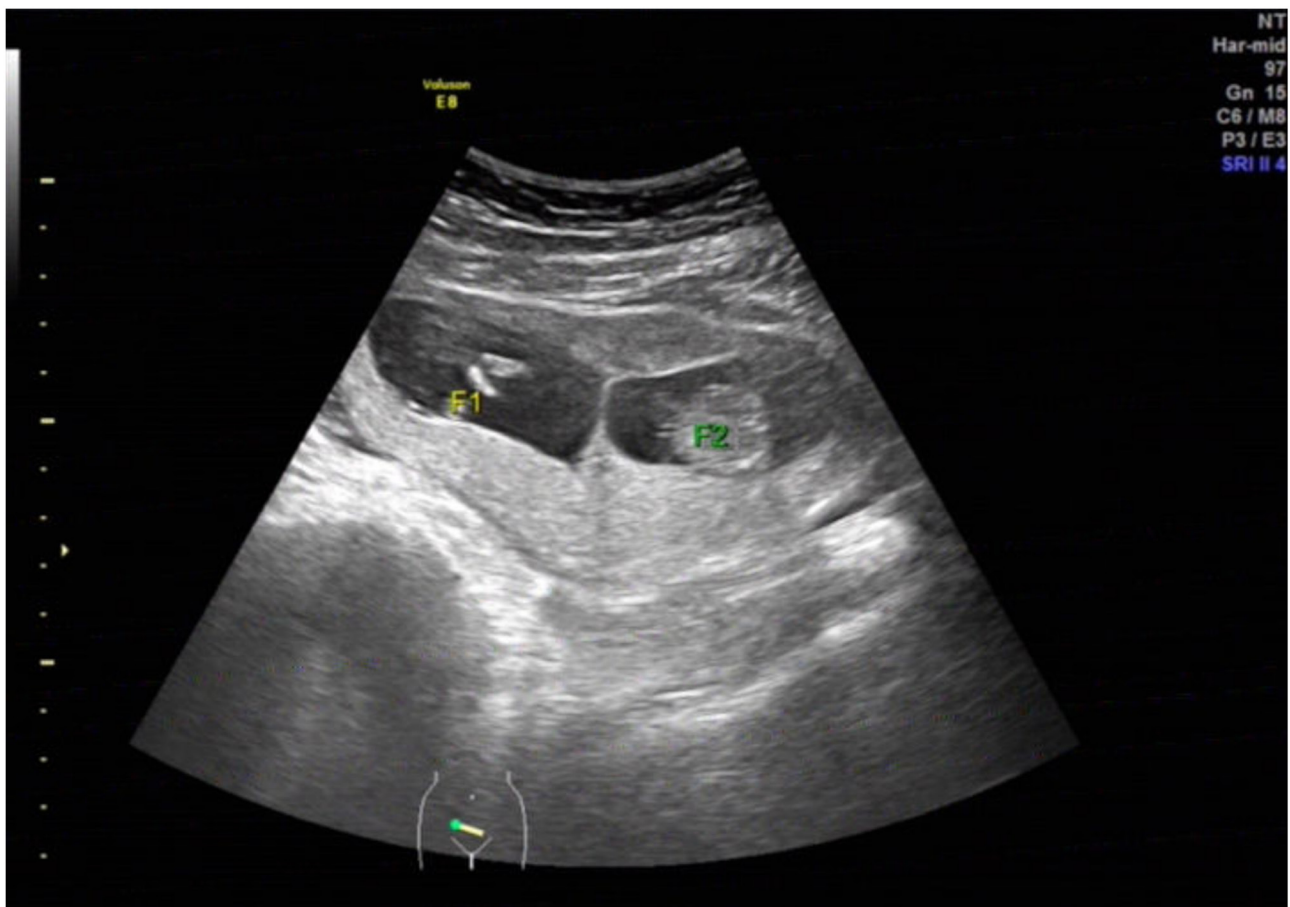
Doppler ultrasound reveals twin pregnancy in the present patient.
